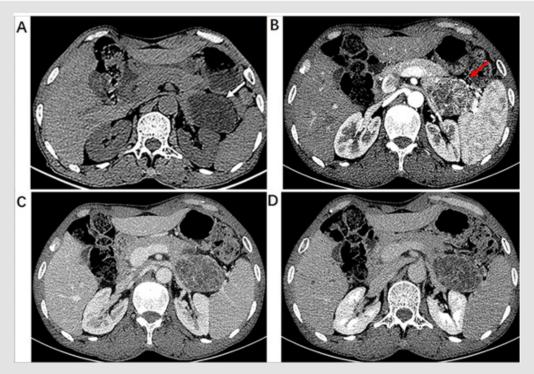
62-year-old male with pancreatic hemangioma. (A) Plain CT scan of upper abdomen showed well-circumscribed multilocular cysts with septa lesion in the tail of the pancreas (white arrow). (B) Enhanced CT scan at arterial phase demonstrated a mass with markedly enhanced septa in the shape of spoke-wheel (red arrow). Portal vein phase (C) and delay phase(D) showed the enhanced reduction of the separations.
